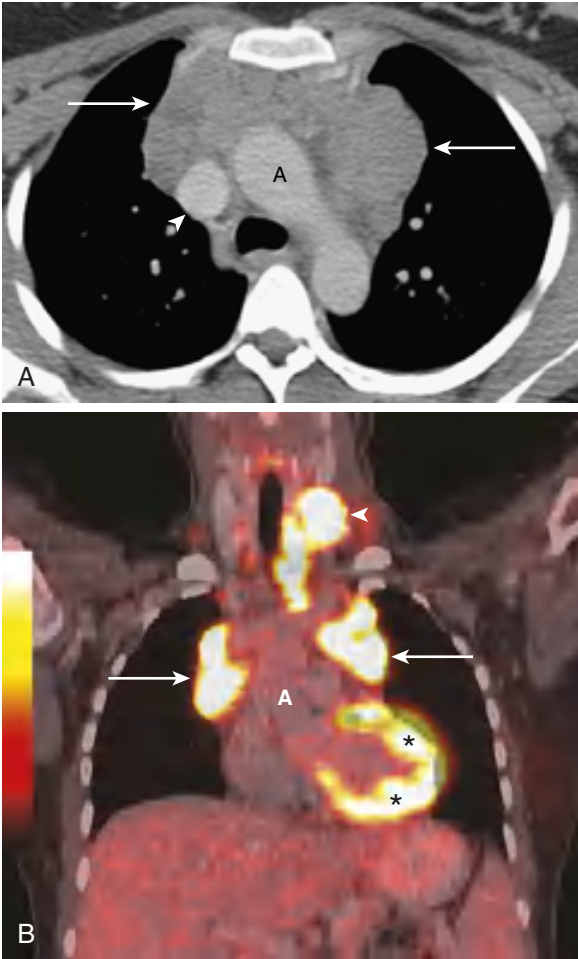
Hodgkin lymphoma in a young individual. A, CT shows a homogeneous anterior mediastinal mass (arrows). The arrowhead points to the superior vena cava. B, PET/CT in the coronal plane. The mass shows marked fluorodeoxyglucose (FDG) activity (arrows). Note the associated left neck mass (arrowhead). The left ventricle activity (asterisks) is normal. A, Ascending aorta. (From Haaga JR, Boll DT, et al., eds. *CT and MRI of the Whole Body* [Vol. 1]. Philadelphia: Elsevier; 2017: Fig. 38-89, p. 1065.)
